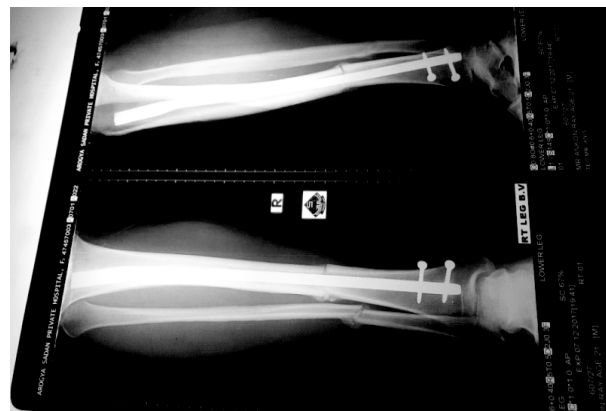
Radiograph at 8 week
